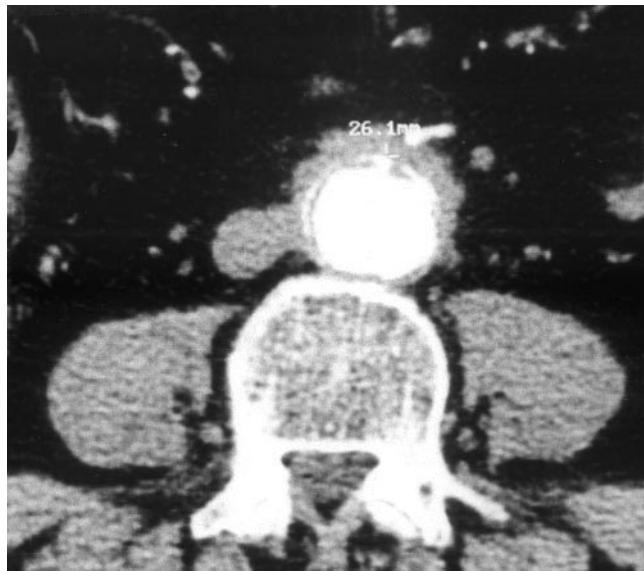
Abdominal CT scan with contrast injection showing an ectasia of infrarenal aorta with parietal calcifications evoking an atheromatous process and a periaortic inflammatory infiltration on lateral and anterior walls.
